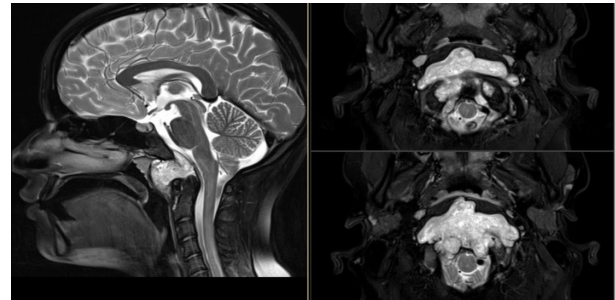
MRI scans of chordoma; Sagittal (left) and Axial (right) T2 MRI with fat suppression
